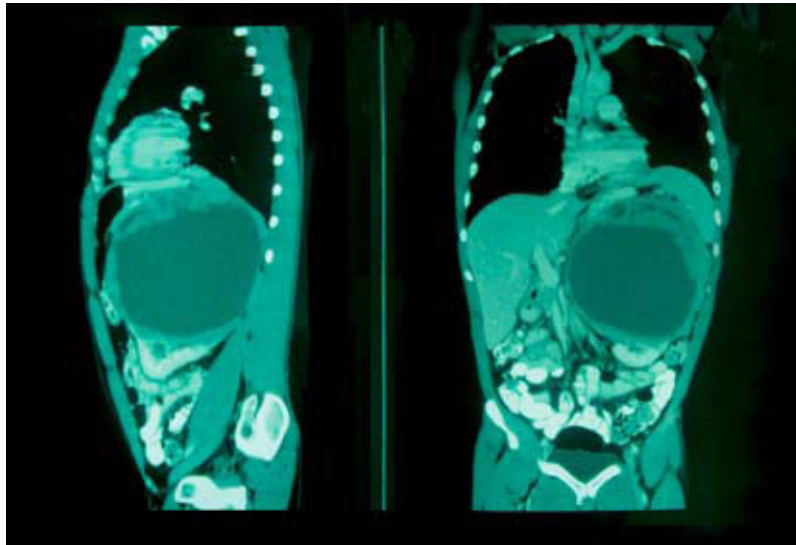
Sagittal and coronal sections of the thorax, abdomen and pelvic CT showing a large cystic mass pending from the upper pole of the left kidney.
